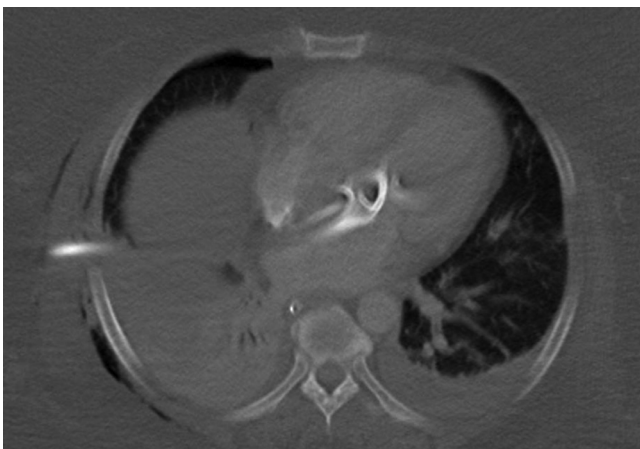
Chest CT axial image with bone window shows catheter traversing the interatrial septum and terminating just anterior to the left atrium
